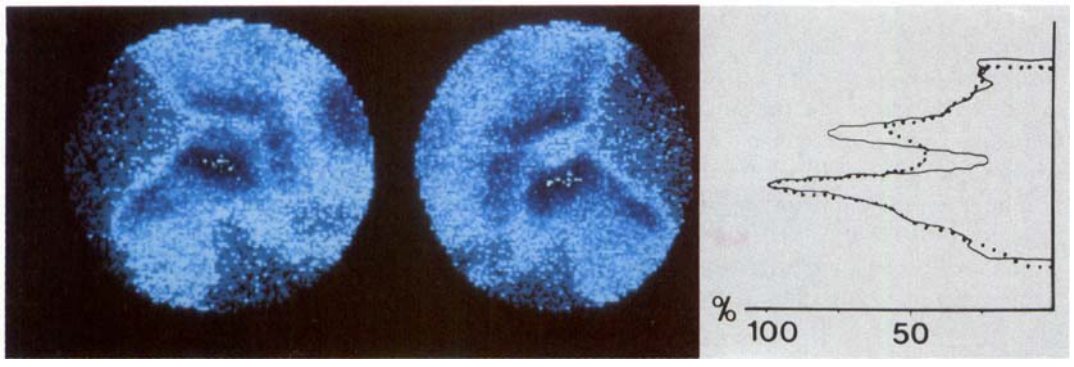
Case 1 with transient ischaemia of the epiphysis of the right hip. This patient did not develop radiographic evidence of LCPD.
